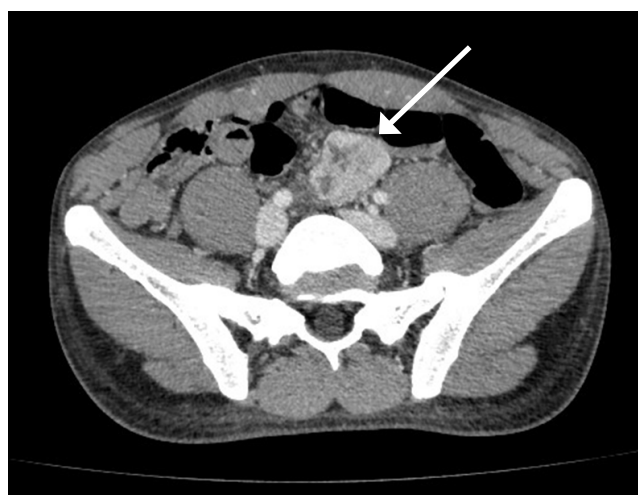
Contrasted CT of the abdomen demonstrating a small bowel mass (white arrow)
